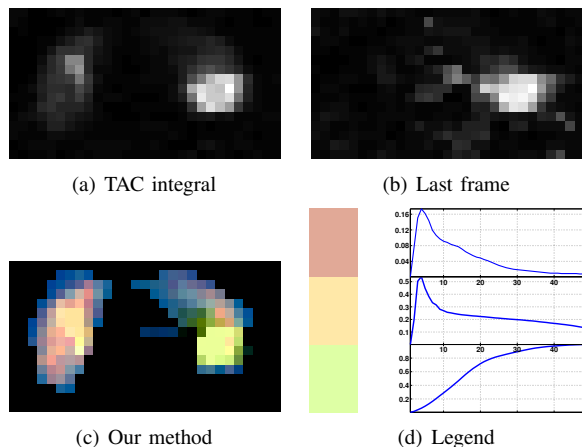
Left and right kidneys shown in a coronal slice from a dSPECT study of renal function. Three display methods are compared: (a) The integral of the dSPECT TAC at every pixel; (b) the activity of the last frame in the TAC; and (c) our method. Note how the pathological lower third of the left kidney (in the right side of the image in (c)) stands out in bright yellow, relative to the other regions of the kidneys. (d) The three key colors (brown, orange, yellow) and corresponding TACs (Section III-F and Algorithm 1) used to produce (c).
